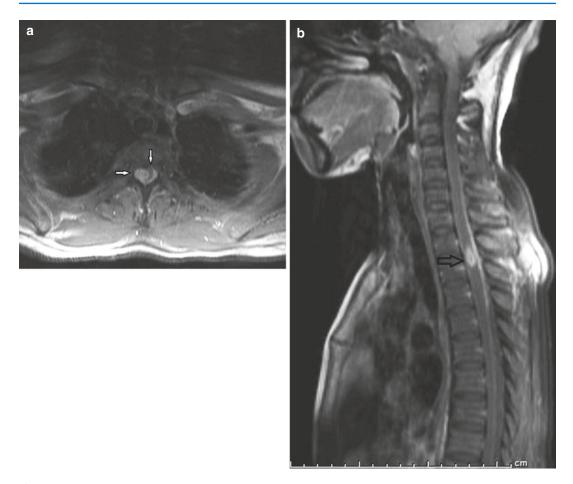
Axial (a) and sagittal (b) fat-suppressed contrast-enhanced T1-weighted images show a contrast-enhancement lesion (tuberculoma) and displacement of spinal cord at T1–T2 level (*arrows*)
